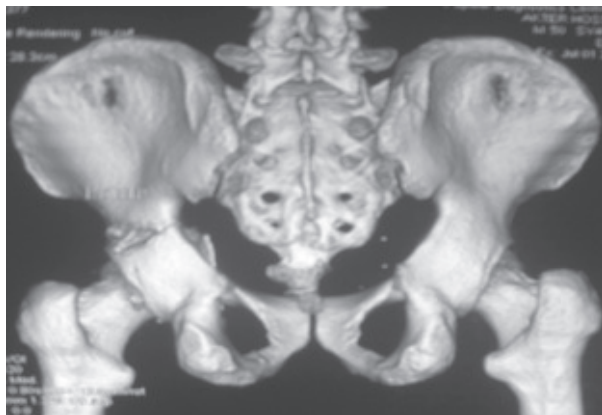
CT reconstruction showing posterior column fracture
